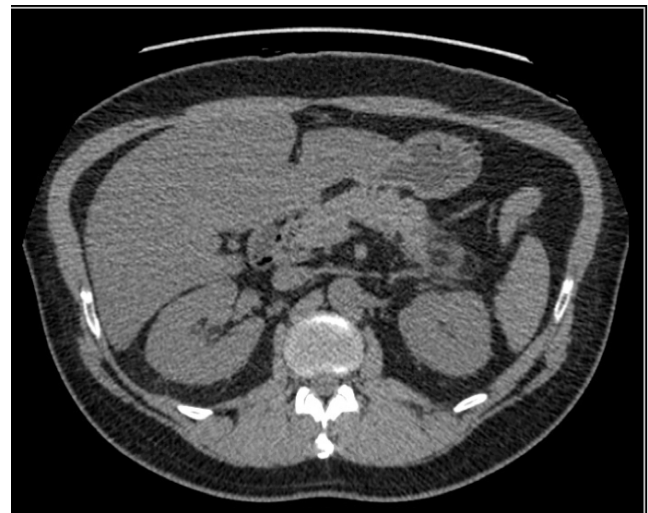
Plain computed tomography of the abdomen
